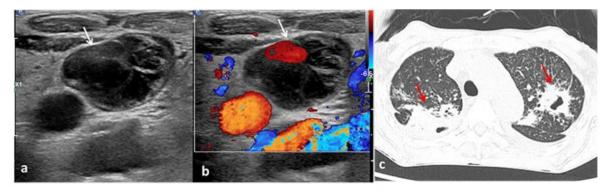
Transverse ultrasound (a) and color doppler (b) images of a 63-year-old female demonstrate hyperechoic thrombus within the distended left internal jugular vein (IJV) with lack of vascular flow signal (white arrows). Axial CT chest (c) demonstrates cavitary lesions in both lungs (red arrows) consistent with a known disseminated tuberculosis.
